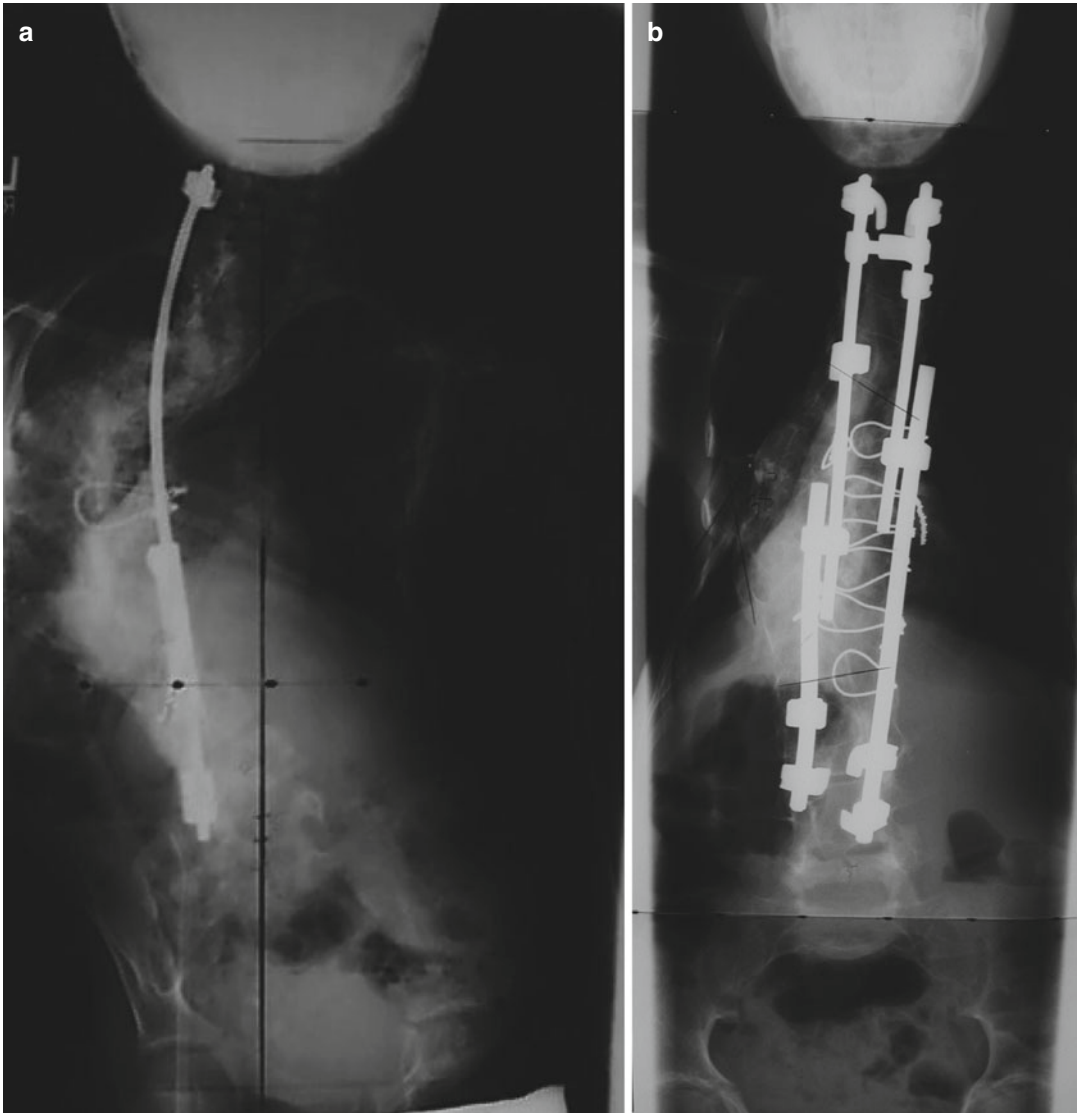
A 7-year-old female with Marfan's syndrome diagnosed with scoliosis at 3 years old, who had undergone bracing and growing rods and then had loss of proximal implant fixation and crankshaft phenomenon after definitive fusion. Revision operative management was slightly delayed due to her emaciated state and need for nutritional optimization by gastroenterology consultation, along with placement of a gastrostomy tube and enteral supplementation. (a) An anteroposterior radiograph taken prior to the revision surgery showing loss of proximal fixation, main thoracic apex left curve from T5 to T12 measuring 128° and a 35° curve from T12 to L5. After application of preoperative traction, the T5–T12 curve was reduced to 108° . She had global kyphosis of 60° , was
